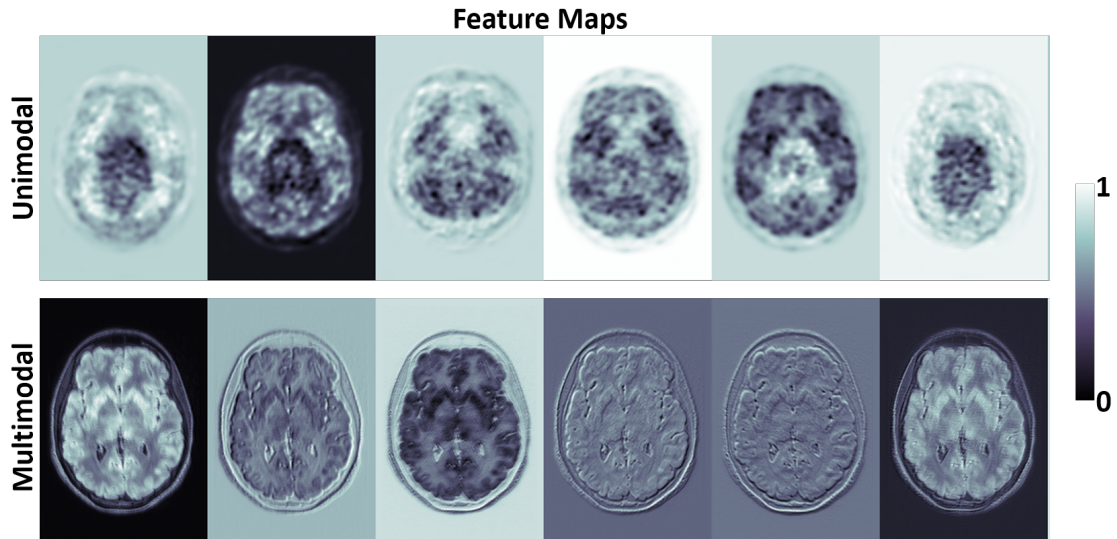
Feature maps obtained from initial layers of the proposed network with unimodal (PET) and multimodal inputs (PET and multi-contrast MRI). Six feature maps are shown out of 64 feature maps obtained at the output of the second layer of the DNN.
